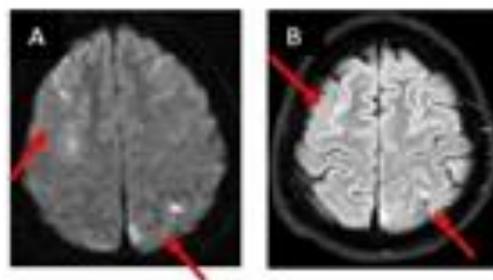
Brain MRI findings on the 1st day showed high intensity on DWI (A) and the lesions improved on the 9th day FLAIR images (B)
